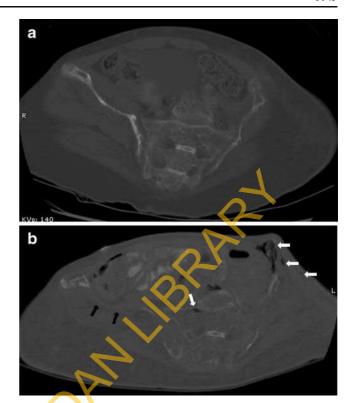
CT scan images demonstrate the progressive osteolysis and bone deformity at the age of 15 (Fig. 4a) and 18 years (Fig. 4b). In certain areas, the full thickness of the bone is replaced by soft tissue density (black arrows in Fig. 4b). Osseous and periosseous pneumatosis is also seen (white arrows in Fig. 4b)
